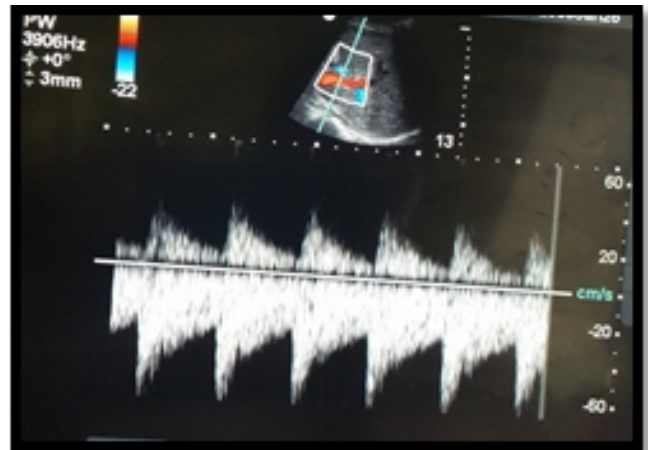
Tri-phasic Doppler flow in hepatic artery after reconstruction
